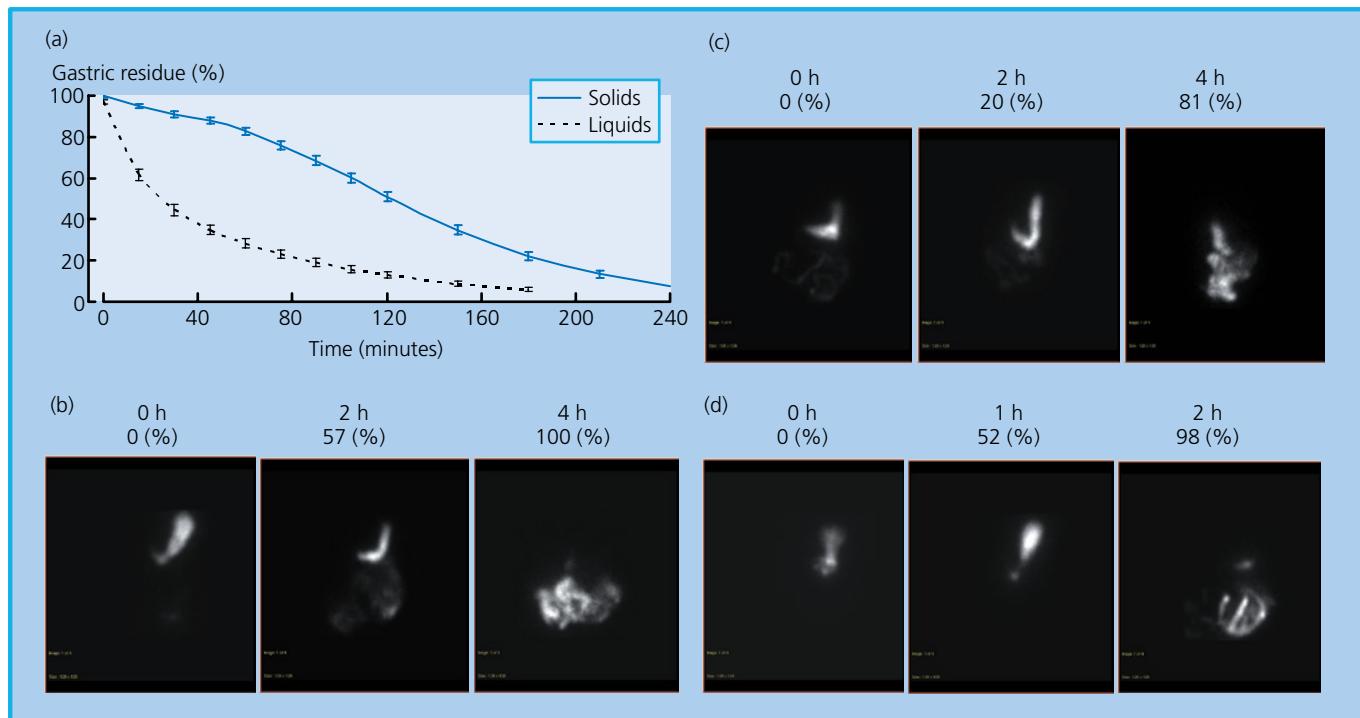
Assessment of gastric emptying by scintigraphy. Normally liquids are emptied in a linear manner, whereas solid emptying has an exponential profile, characterized by an initial lag phase, followed by a more rapid, linear emptying (a). The lag phase corresponds to the time required for antral trituration and gastric accommodation, during which ~10% of solids are emptied (b–d). Representative
